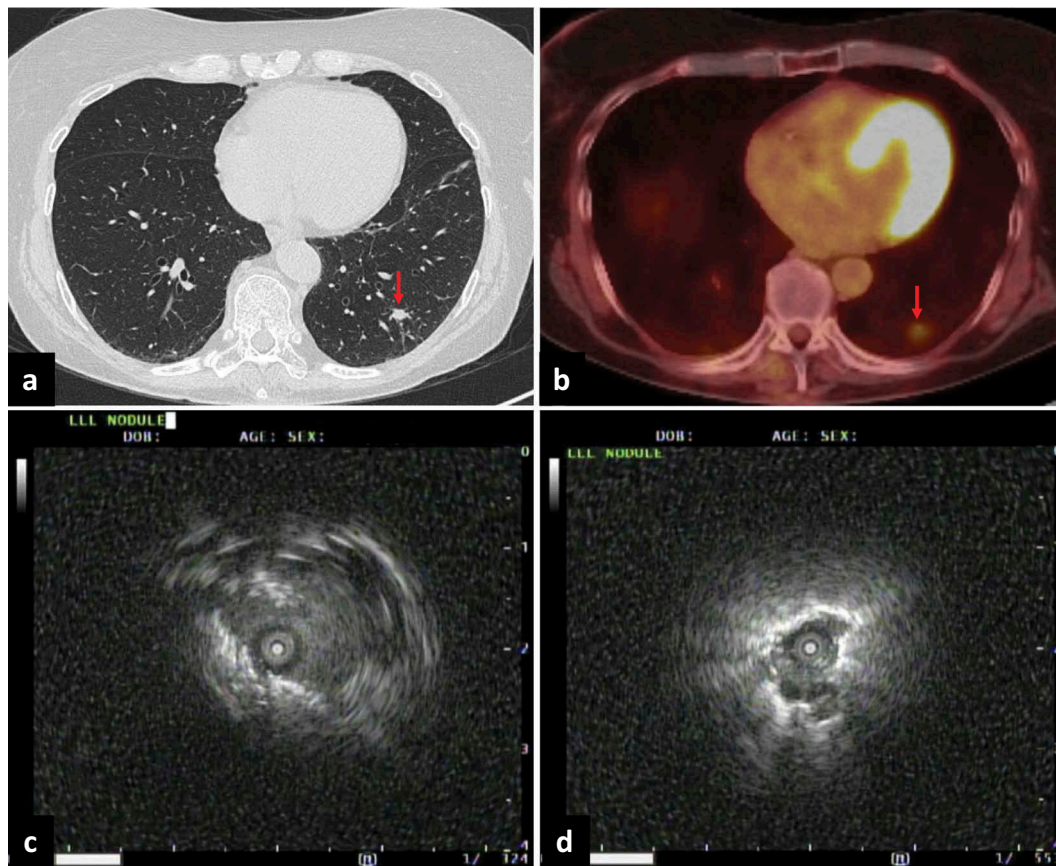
'Drop-off' from successful electromagnetic navigation and nodule-localization to nondiagnostic biopsy. A 67-year-old woman with a left lower lobe nodule measuring 8×7 mm on CT (a, arrow) with a maximum standardized uptake value of 3.3 on PET-CT (b, arrow). Despite successful electromagnetic navigation confirmed via radial endobronchial ultrasound (c, d), cytology was nondiagnostic. Subsequent surgical resection revealed a diagnosis of histoplasmosis.
